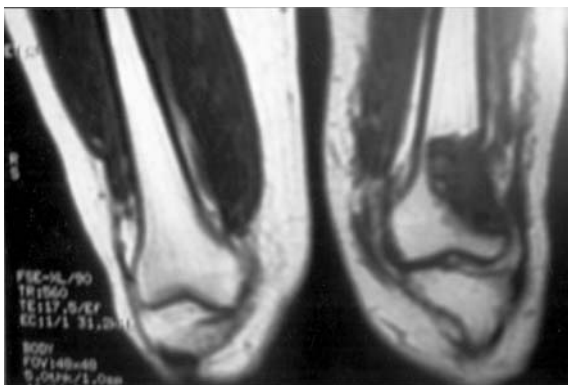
Pre-operative MRI for a patient with GCT lower femur.
